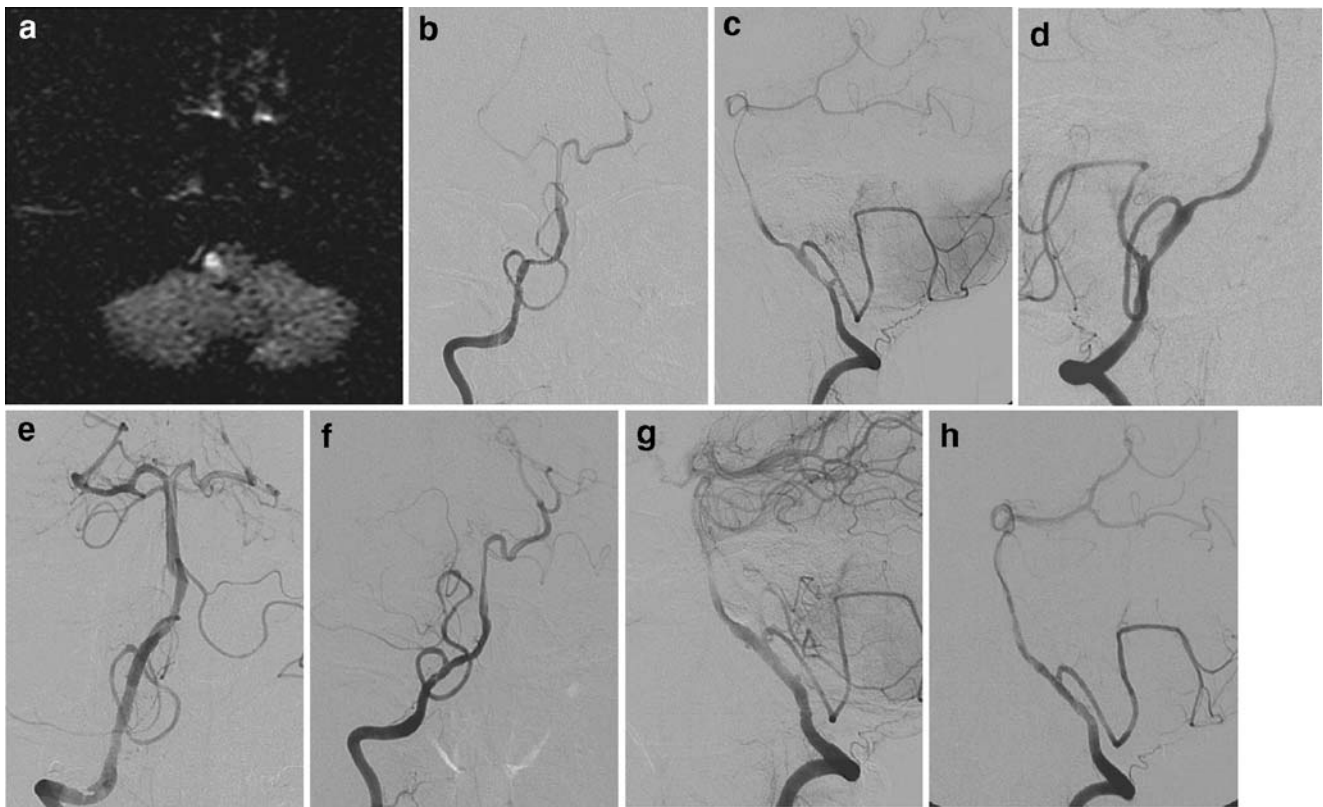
Patient 4. a Diffuse weighted MRI image obtained on admission shows a high signal intensity lesion on the right medulla corresponding to a lateral medullary infarction. b–d Initial angiograms reveal concentric luminal narrowing with intramural hematoma of the right VA with PICA involvement. e, f Follow-up angiograms acquired
